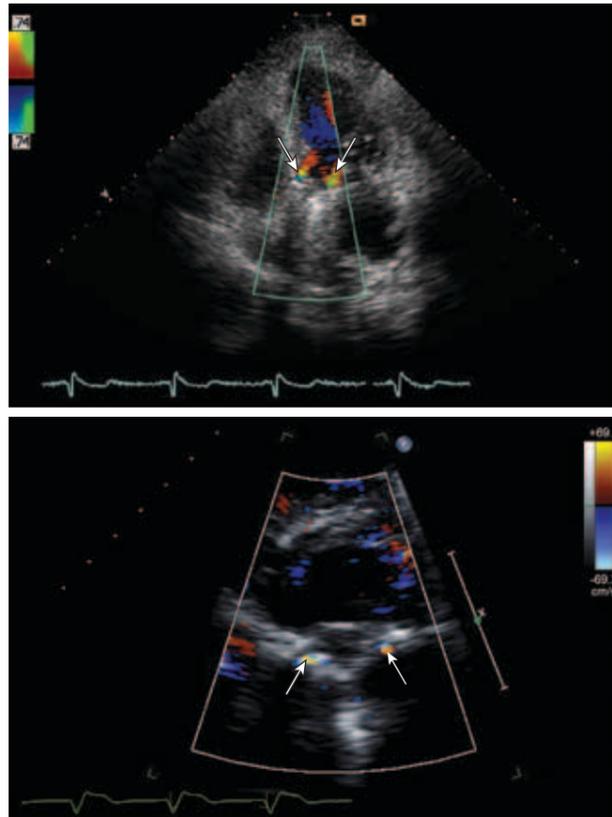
Normal leakage volume regurgitation through bileaflet tilting disc valves in the aortic and mitral position are shown; images were acquired from two different patients. The image of the aortic prosthesis was recorded from the apical 5-chamber view (top). The image of the mitral prosthesis was recorded from the parasternal short axis view (bottom). Observe that these normal jets appear at the periphery of the valve where the closed discs meet the housing (arrows). The jets appear short and narrow in the case of the aortic prosthesis and small in area in the case of the mitral prosthesis.
